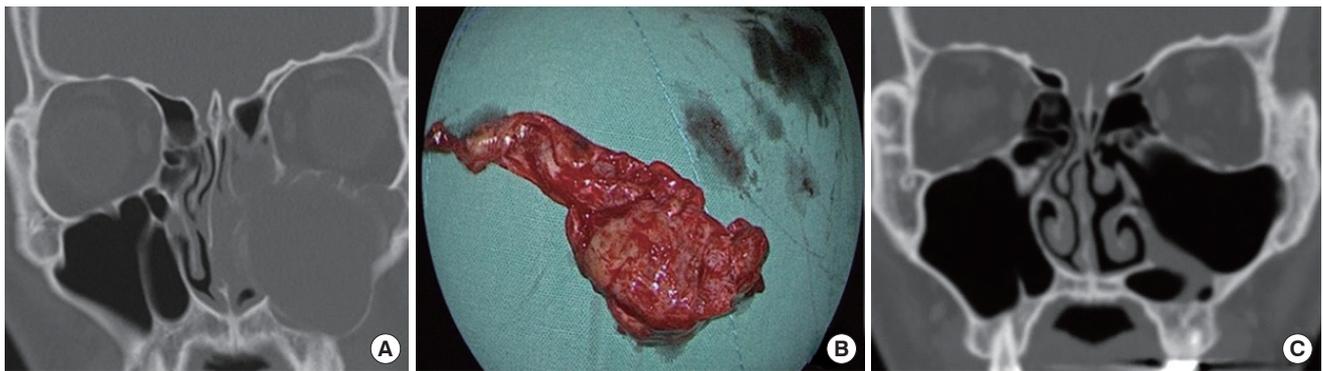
Ameloblastoma excision case using endoscopic prelacrimal medial maxillectomy. (A) Computed tomography (CT) scan showed a large expansile mass in the left maxillary sinus. (B) A well-capsulated round mass was successfully removed. (C) Postoperative 18-month CT scan showed absence of tumorous lesion and well-pneumatized maxillary sinus.
